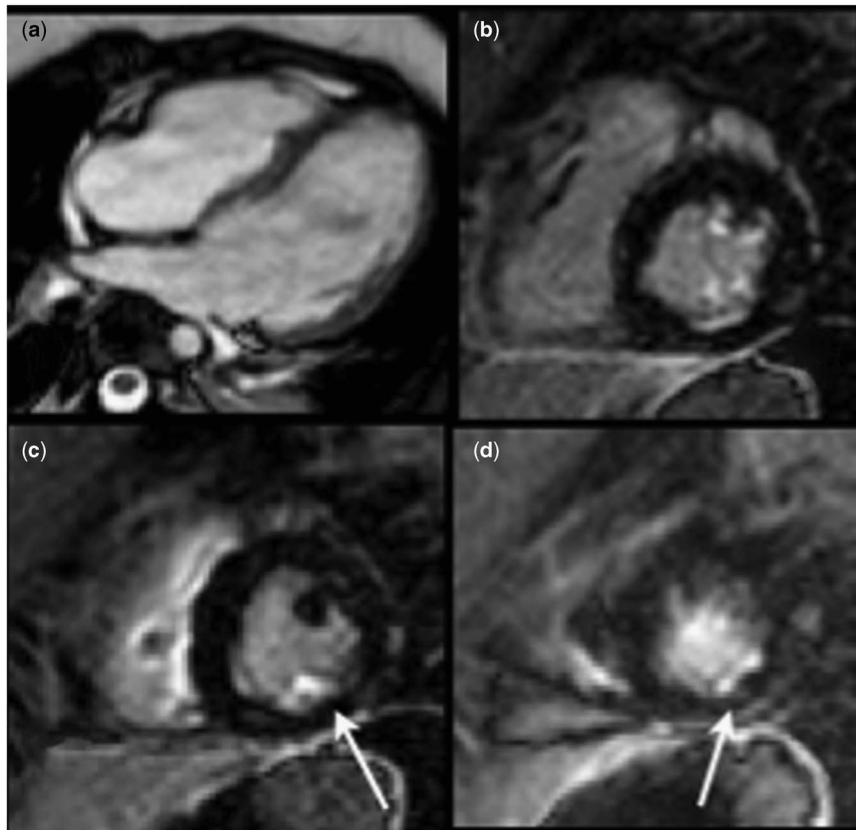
Images from initial cardiac MRI performed on patient who was in respiratory distress with heart rate averaging at 155 beats per minute during the examination. Patient was intubated but freely breathing during examination. (a) Images from axial cine SSFP showing thrombus in right atrium (arrow) and (b) in right ventricle (arrow); perfusion imaging in short axis at mid ventricle (c) showing decrease perfusion at the inferomedial papillary muscle and adjacent endocardium (arrow) and near apex (d) showing decrease perfusion in endocardium (arrow); there was no blood pool signal in the right ventricle because of presence of thrombus (\*). Viability imaging with PSIR in short axis (e, f) showed diffuse areas of LGE along the endocardial surfaces of both right and left ventricles. LGE = late gadolinium enhancement; PSIR = phase sensitive inversion recovery pulse sequence; SSFP = steady-state free precession.
